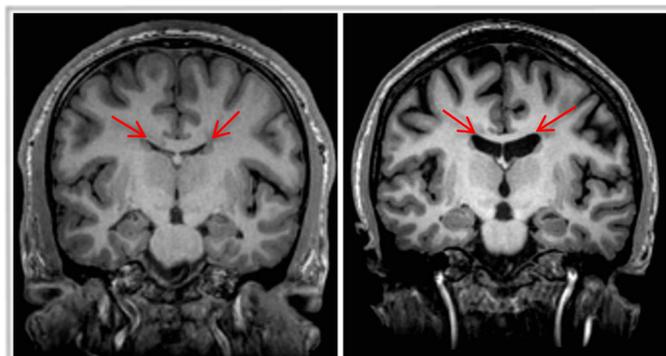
A. Coronal T1-weighted MRI slice of a representative control subject and B. of a representative FESZ patient. Arrows indicate the CC and LV.
